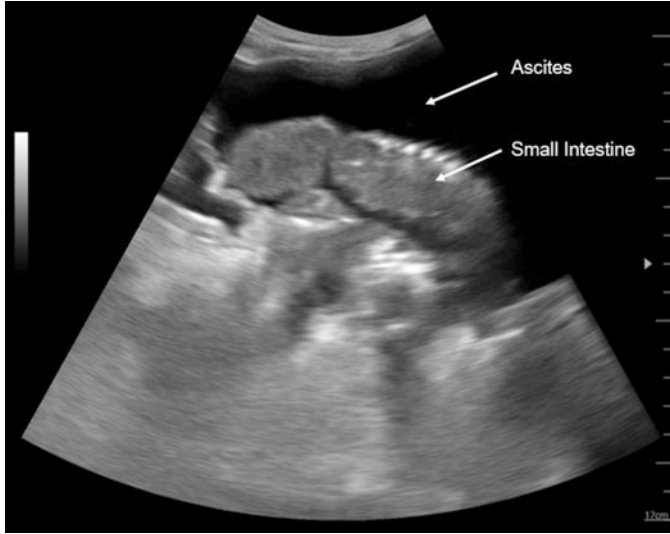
Ascites is primarily composed of water and appears black in ultrasound. In this image a loop of intestine is seen floating in ascites
